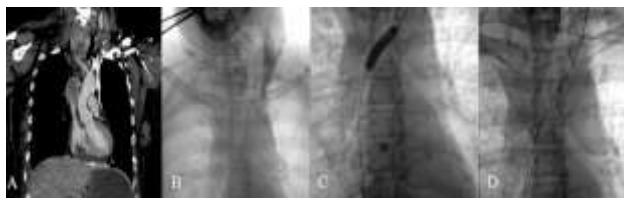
(A-D): Chest contrast-enhanced computed tomography reconstruction showing almost 100% occlusion of the left innominate vein and SVC.
